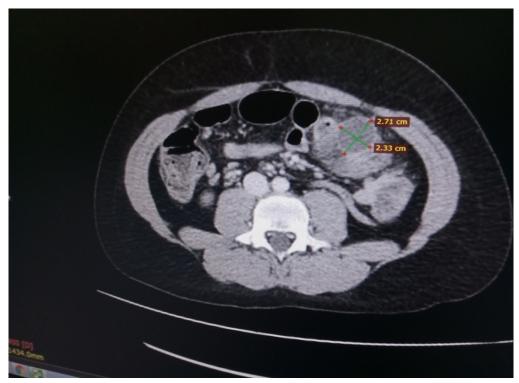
Pseudocyst formation in ileum in contrast-enhanced CT (measuring 2.71x2.33 cm)
